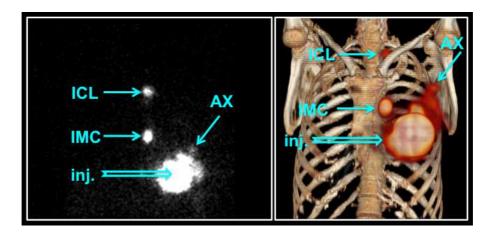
Lymphoscintigraphic mapping obtained after peritumoral injection of 99mTc-nanocolloid in a patient with cancer of the left breast scheduled for surgery and radioguided sentinel lymph node biopsy. Planar images (left panel) show migration of the radiocolloid from the injection site to an axillary sentinel lymph node as well as to additional sentinel nodes in the internal mammary chain and in the infraclavicular space. Topographic location of such lymph nodes, that guide the surgeon for removal, are better shown by 3D volume rendering of a SPECT/CT acquisition (right panel). inj. = injection site; AX = axillary sentinel node; IMC = internal mammary chain sentinel node; ICL = infraclavicular sentinel node.
